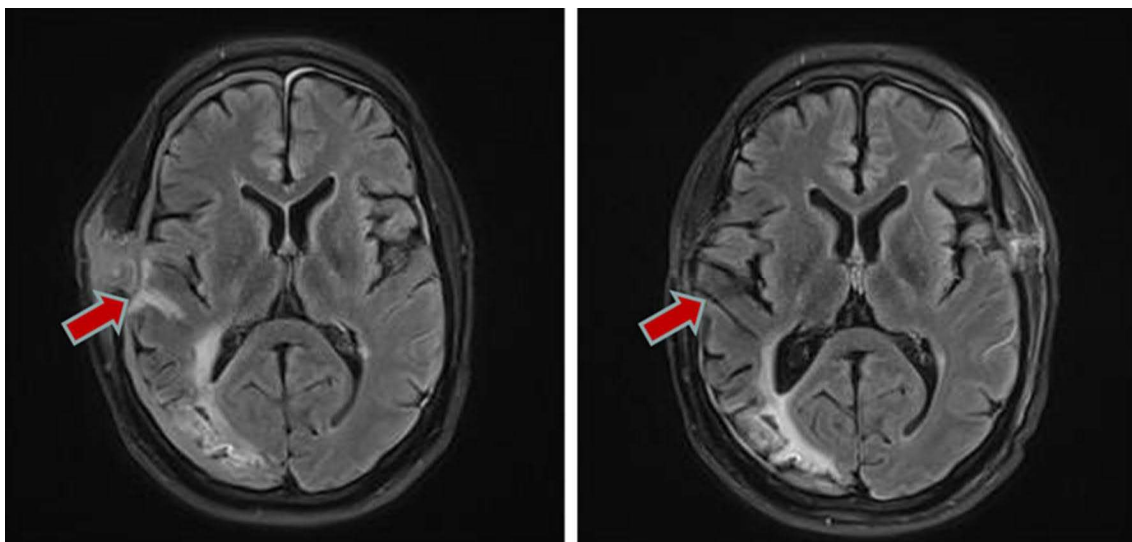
Hyperperfusion syndrome in FLAIR images in MRI (left) at day 6 after surgery and spontaneous recovery (right) after 3 months
